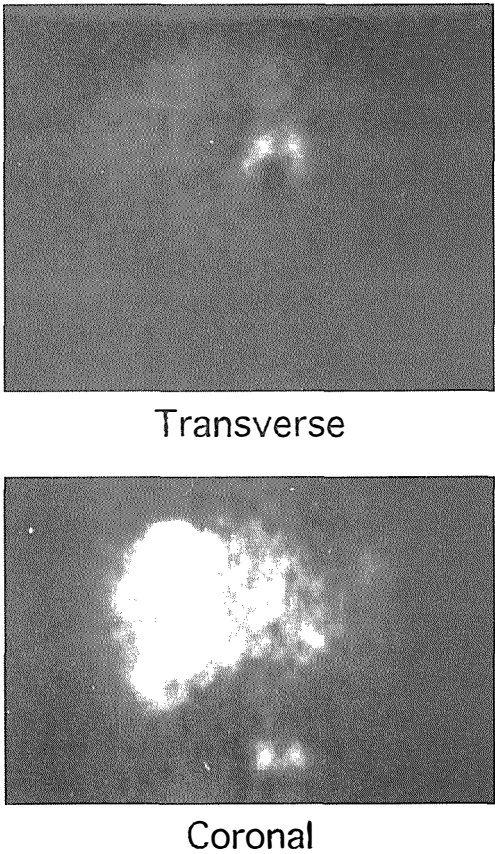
¹¹¹In-octreotide SPECT of abdomen. Unsuspected paraaortic lymph node metastases in patient with liver metastases from coecal carcinoid. a. transversal and b. coronal slice.
